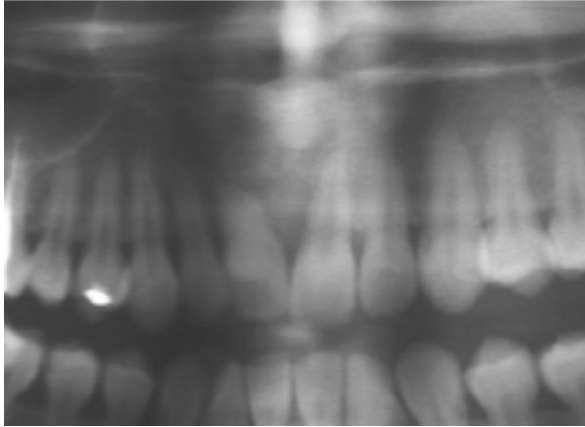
Postoperative 15. months radiography.
